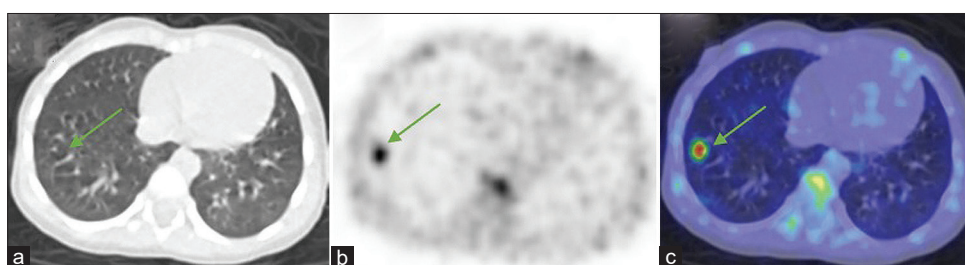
Lung window axial image (a), MIP PET image (b), and axial fused image (c) from FDG PET/CT of a 1-year-old baby with proven ethmoidal spindle cell neoplasm who underwent FDG PET to rule out any other metastasis, showed hypermetabolic hot spot in MIP PET and fused PET/CT images in the right lower lobe without anatomic correlate (corresponding to green arrow).
